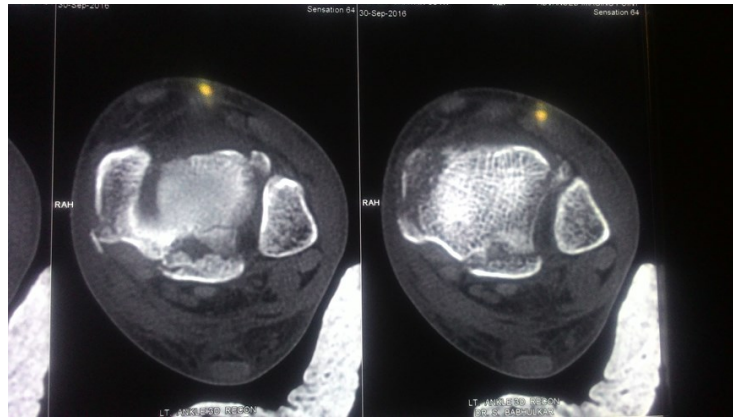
Axial CT scans showing postero-lateral fragment of posterior malleolus confirming the size of Posterior malleolus.
